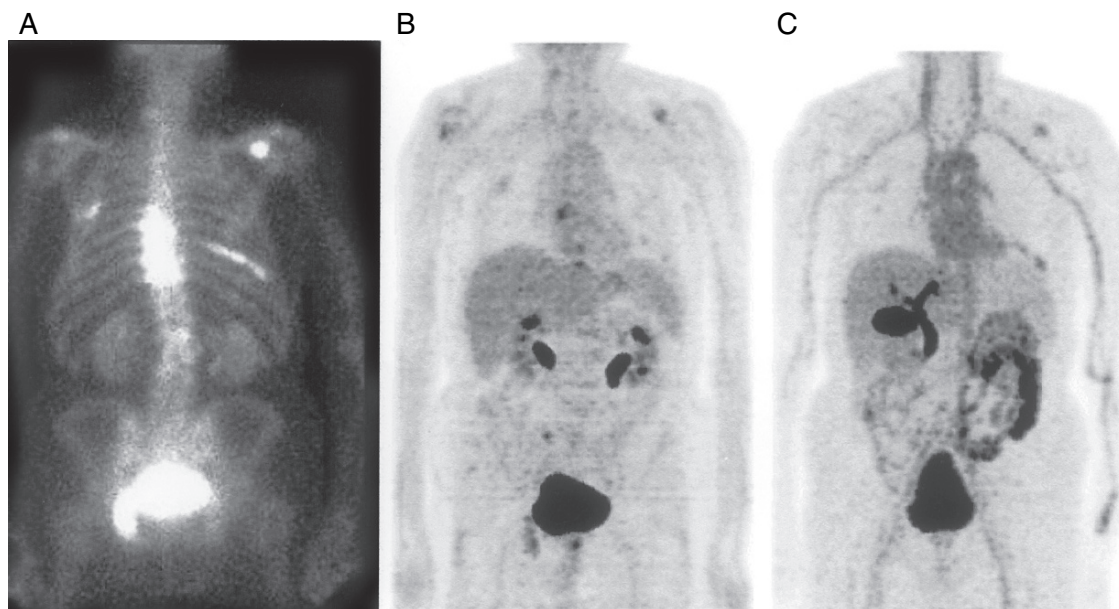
Comparative whole-body images of a 75-year-old man with progressive PC metastatic to bones of the thoracic spine, left rib cage, and scapula. (A) Planar gamma camera image of ^{99m}Tc -methylene di-phosphonate (MDP). (B) Coronal PET image of [^{18}F]FDG. (C) Coronal PET image of [^{18}F]FDHT. (Adapted from Zanzonico *et al.*, 2004 by permission of the authors.)
